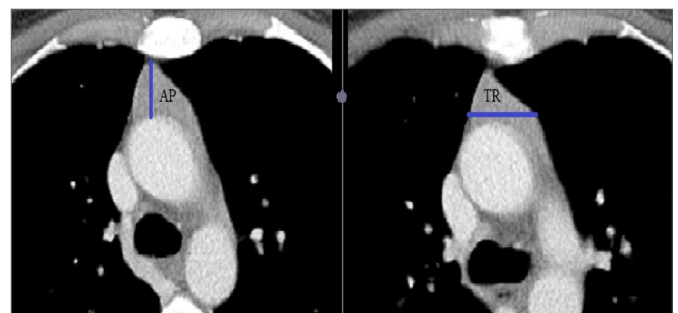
The measurements of anteroposterior (AP) and transverse (TR) diameters from the thickest point of the gland on axial CT images.
